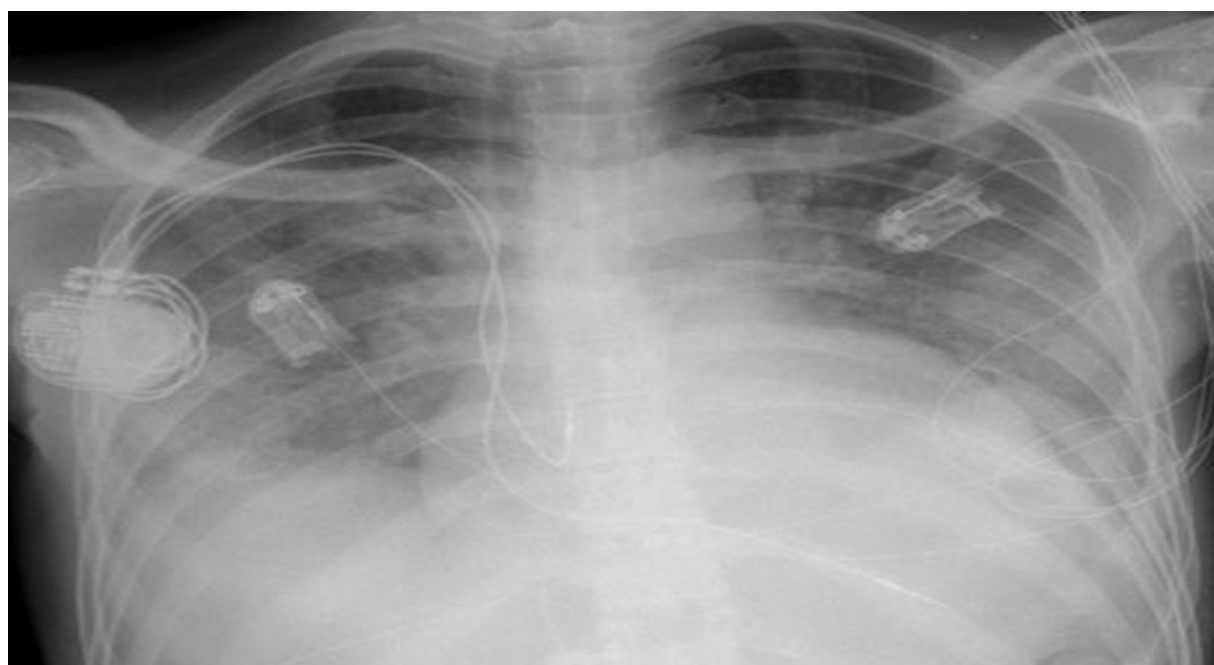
Bedside PA chest x-ray showing cardiomegaly and pulmonary congestion. In addition, a right-sided dual-chamber pacemaker can be observed.
